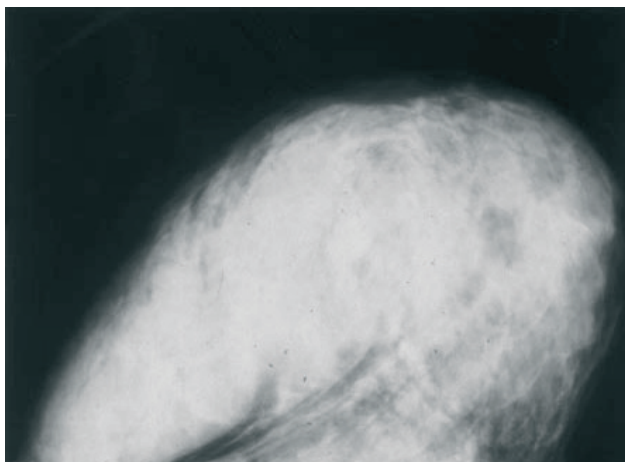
Craniocaudal oblique view of the mammography of the right breast of patient B, performed after detection of the suspect lesion with MRI, clearly shows dense breast tissue and not the malignancy.
